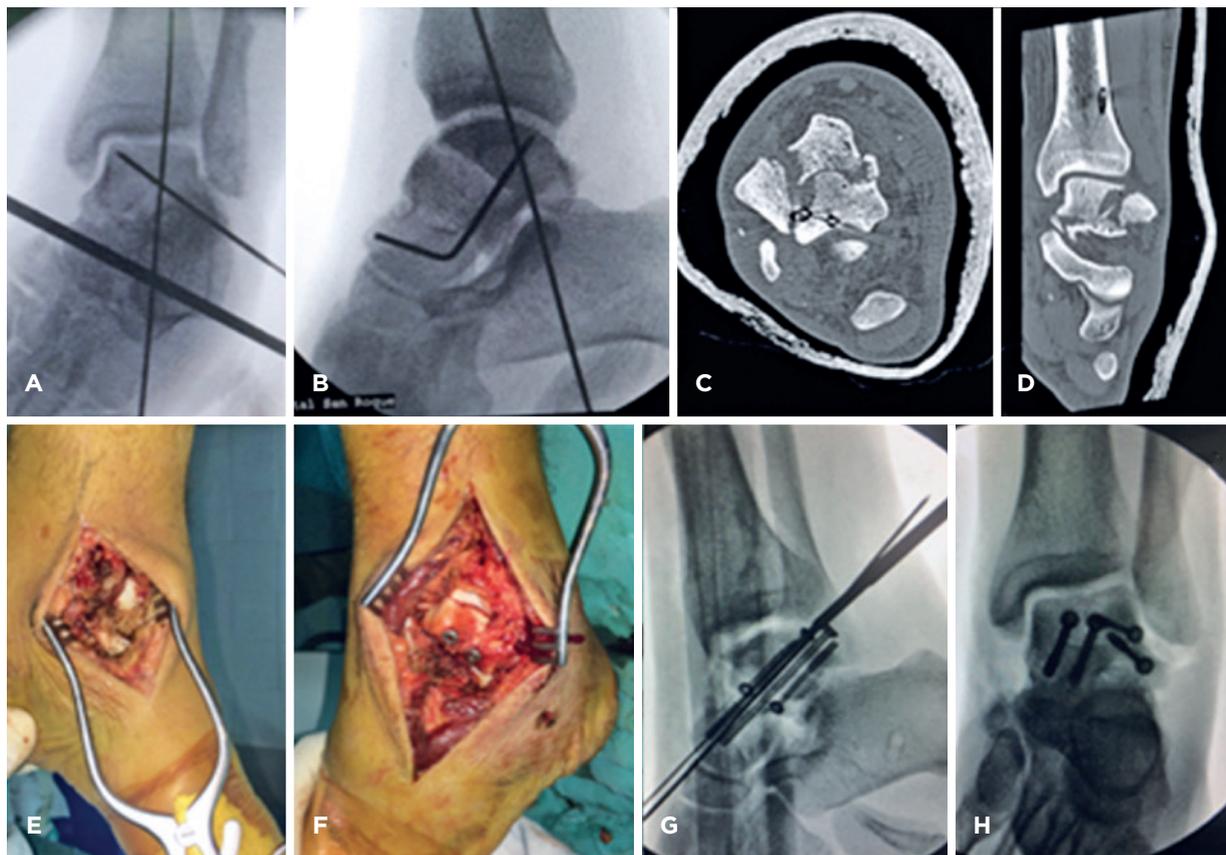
Sample Case. Description: (A and B) Anteroposterior and lateral radiographs of the talus after initial closed reduction. (C and D) Post-reduction axial computed tomography. (E) Anteromedial approach. (F) Anterolateral approach. (G and H) Anteroposterior and lateral radiographs of open reduction and internal fixation.
